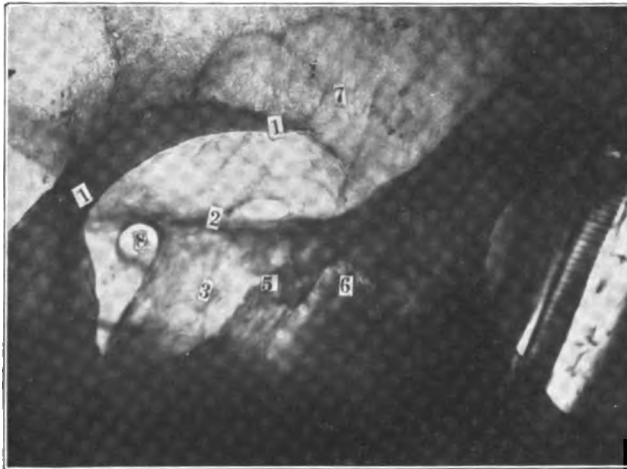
Roentgenogram of dry skull (right side): 1, 1, orbital margin; 2, suture line between frontal bone and lamina papyracea; 3, sphenoid; 5, posterior ethmoids; 6, anterior ethmoids; 7, frontal sinus; 8, optic foramen.
